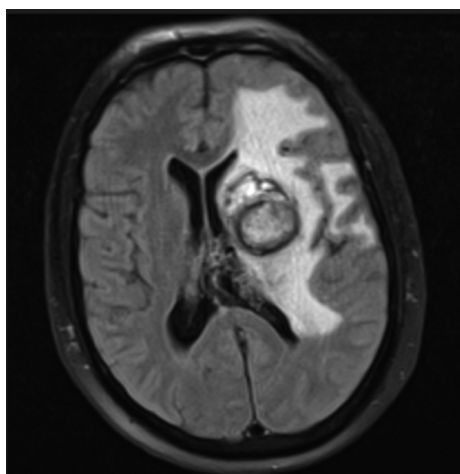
T2-weighted fluid-attenuated inversion recovery: Left central core hemorrhage, in the resorption phase, surrounded by perilesional edema.
